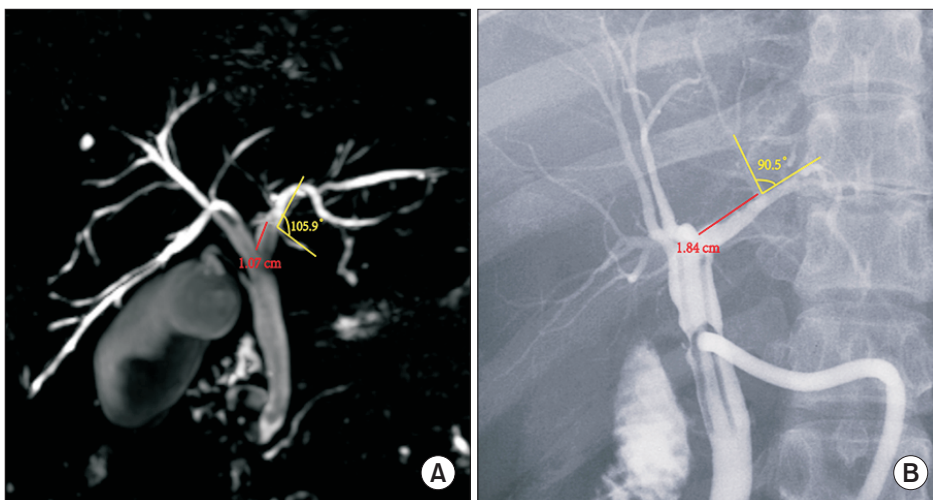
The images of data acquisition in MRI (A) and T-tube cholangiography (B).
